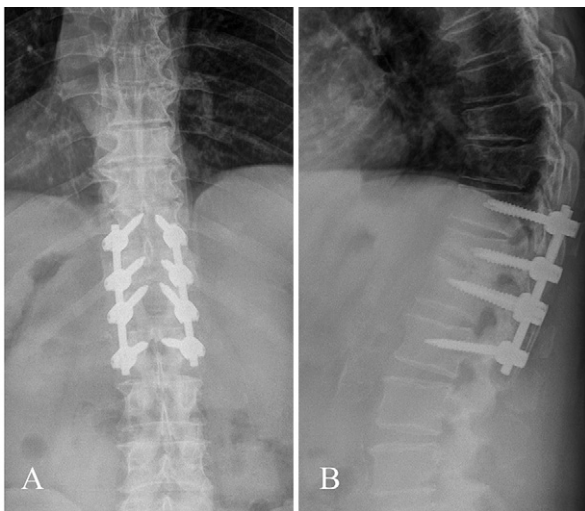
Postoperative radiographs showing T11–L2 posterior instrumentation and debriement.
